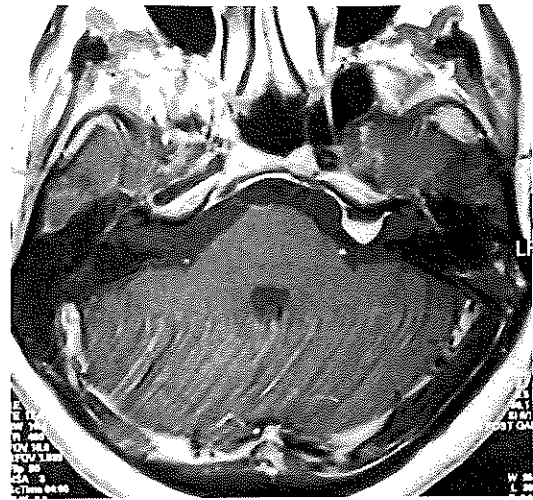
T1-weighted postcontrast axial image of a 10-mm ventral petrous meningioma on the left
